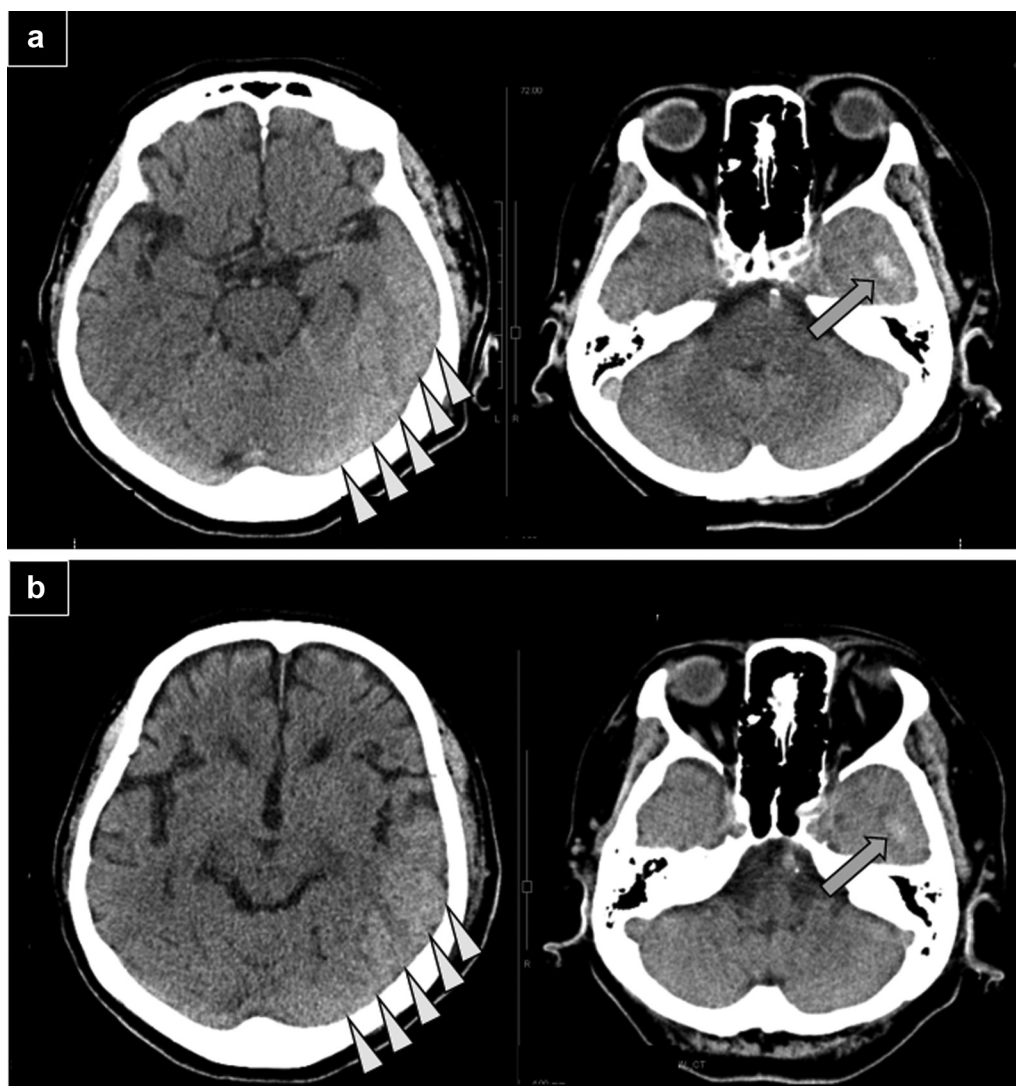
Plain computed tomogram of the patient's head after closure of the arteriovenous graft. One day (a) and 5 days (b) after arteriovenous graft closure. Left temporal lobe bleeding had gradually improved (arrows), as had the congestive edema caused by congestion of the contrast agent (arrowheads).
